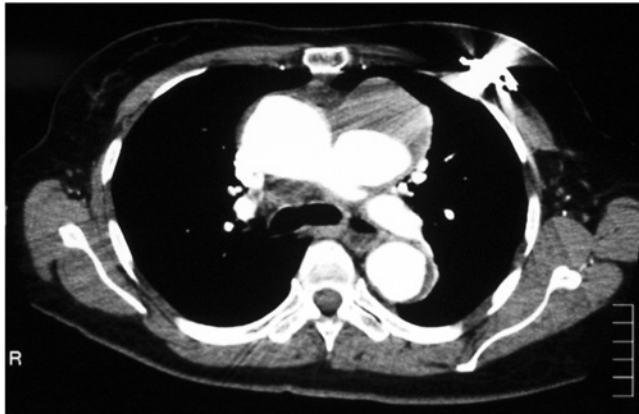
Enhanced CT scan of the chest shows a saccular descending aortic aneurysm just distal to the left subclavian artery.
